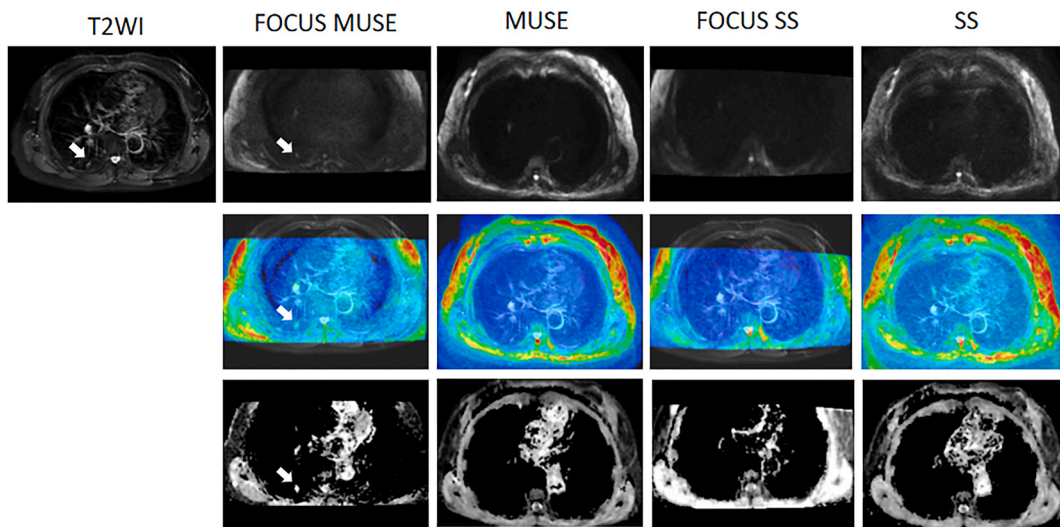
Thirty-one years old woman with adenocarcinomas adjacent to chest wall in right lower lobe. The diameter of tumor is about 1.5 cm. The first row was T2WI and location matched FOCUS MUSE, MUSE, FOCUS SS, and SS DWI images sequentially. The second row was corresponded and enlarged images with DWI overlaid on T2WI. The location of the enlarged region was shown in red rectangle on the T2WI image. The third row was the ADC map accordingly. The overall shape and location of lesion were roughly compatible in FOCUS MUSE relative to T2WI. However, the same lesion was obviously distorted and spatial shifted on SS, FOCUS SS, and MUSE DWI images. (For interpretation of the references to colour in this figure legend, the reader is referred to the Web version of this article.)
